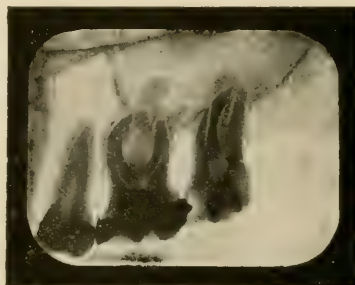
Angle of X-rays, arrow B, Fig. 440.
